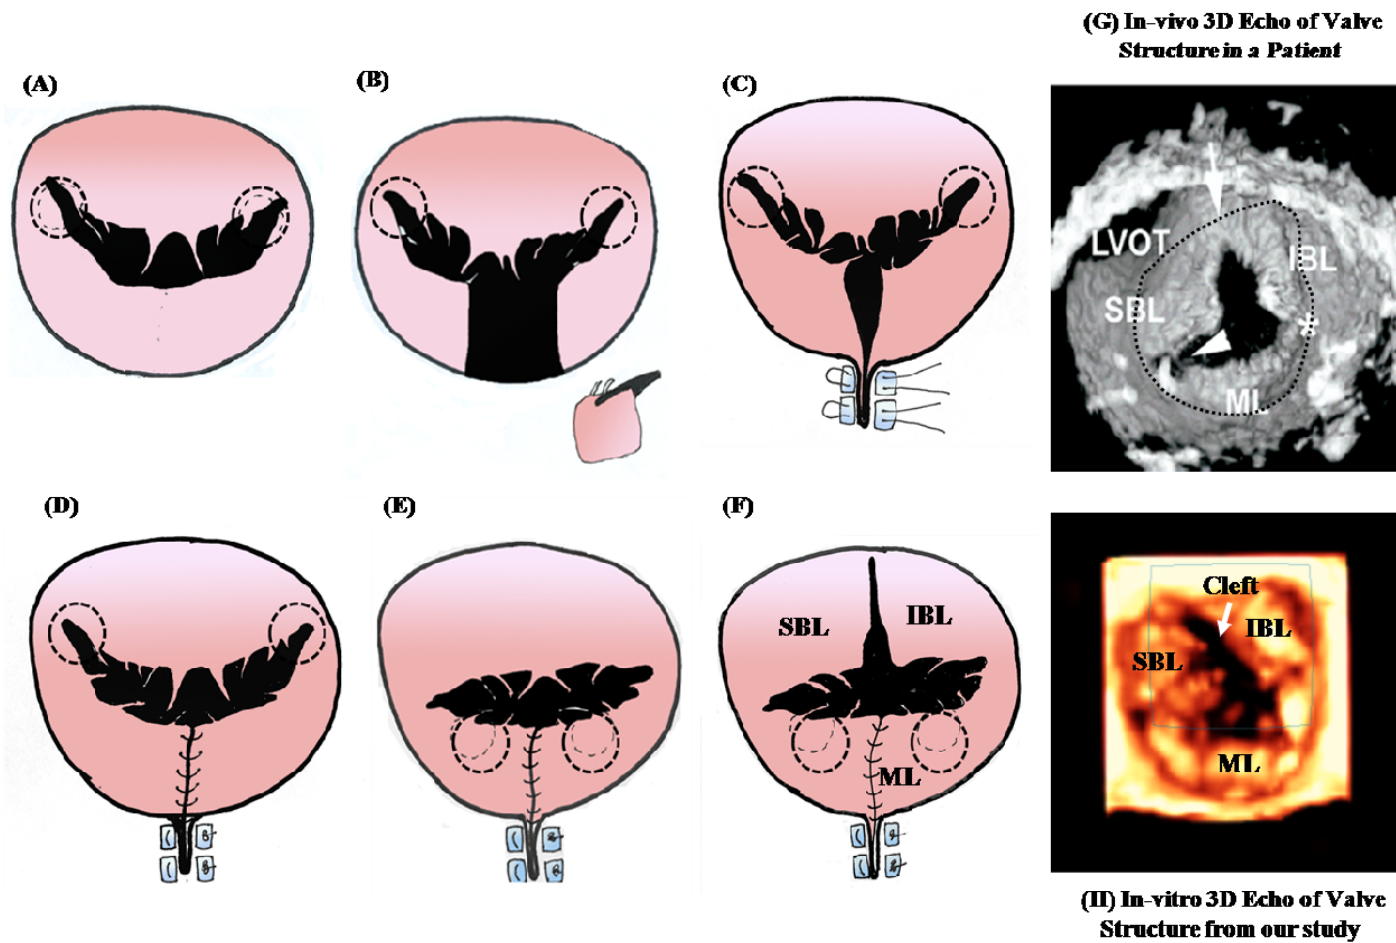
(A-F) Sequential steps to alter the native mitral valve geometry to mimic the left atrioventricular valve in the canal defects. The dotted circles indicate the position of the papillary muscles. The images on the right (G,H) compare the valve structure with cleft (arrow) obtained from our *in-vitro* setup under pulsatile hemodynamic conditions with one obtained from a patient, using 3D echocardiography. SBL: Superior Bridging Leaflet, IBL: Inferior Bridging Leaflet, ML: Mural/Posterior Leaflet
